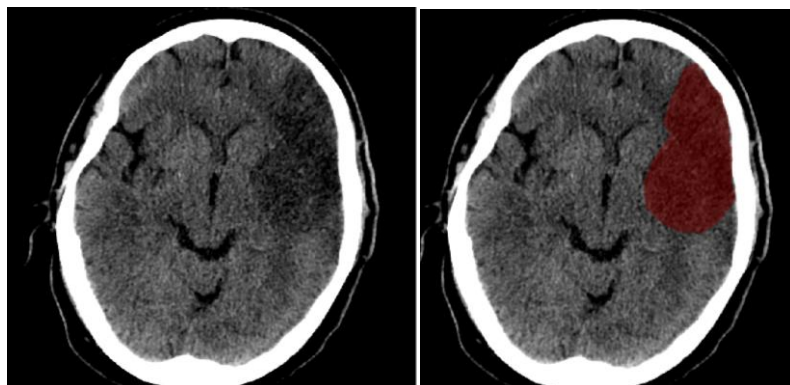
CT Infarction ROI
